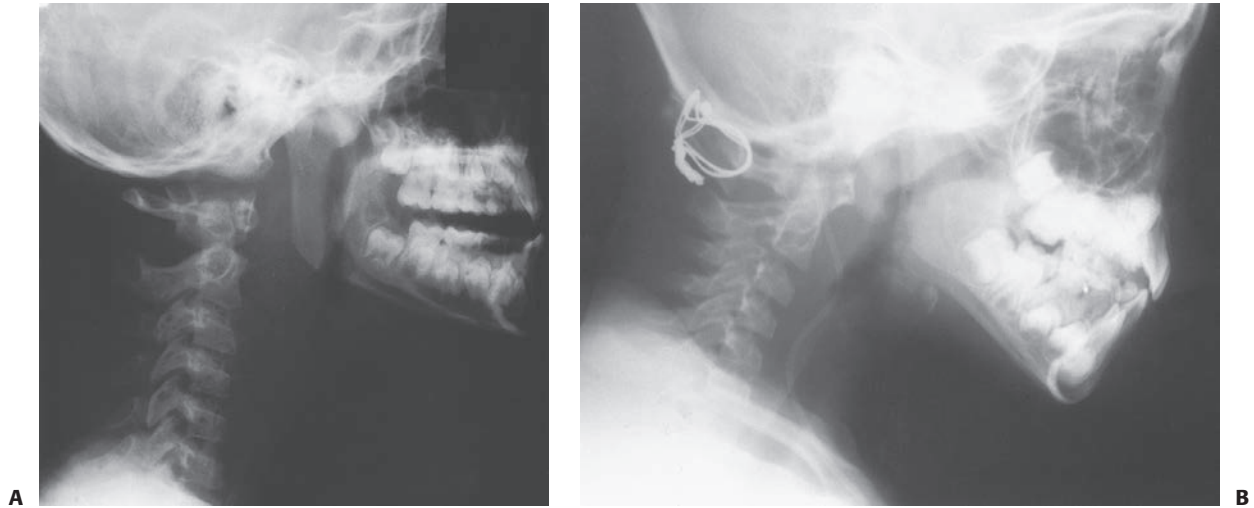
A: Lateral radiograph of a patient with atlantooccipital dislocation. Note the increase in the facet condylar distance. B: Lateral radiograph after occipital C1 arthrodesis.
